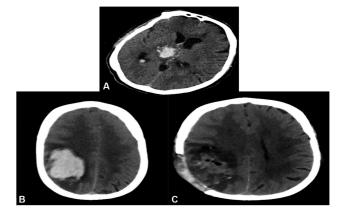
(A) Computerized tomography (CT) of a patient with nonoperated intracerebral hemorrhage. (B) Preoperative CTy of a patient with intracerebral hemorrhage. (C) Postoperative CT of a patient with an intracerebral hemorrhage.
